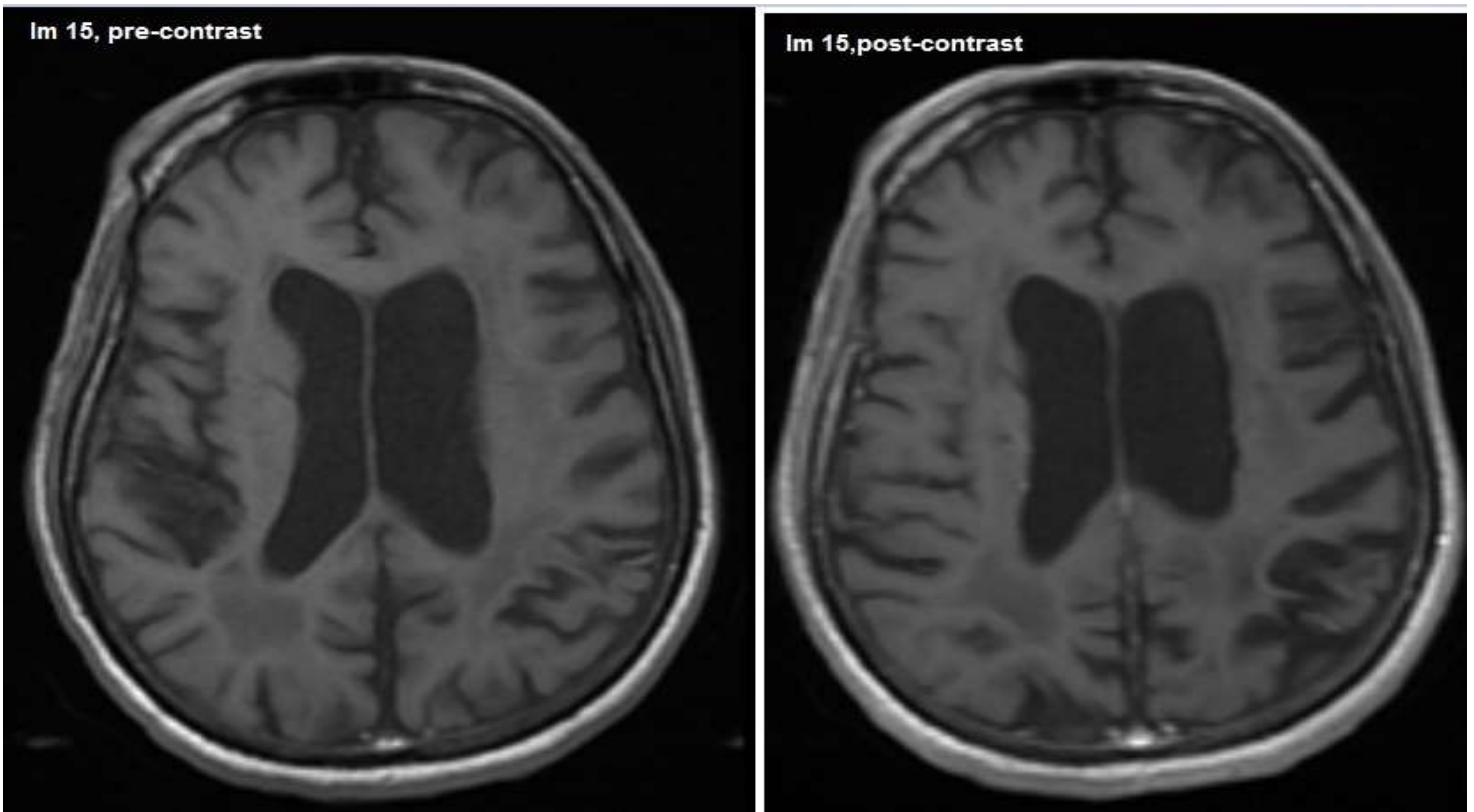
MRI image pre and post contrast-Greater enhancement
